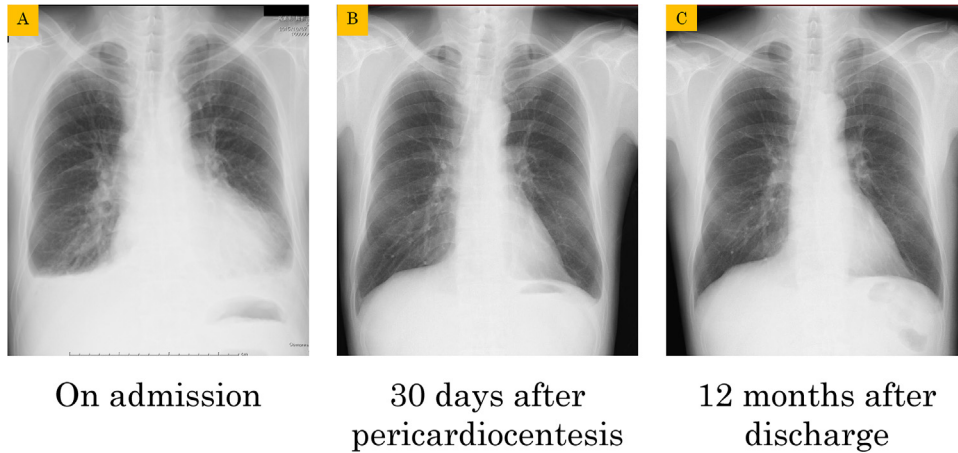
(A) Chest radiography on admission revealed bilateral pleural effusion and an enlarged cardiac shadow with a cardiothoracic ratio of 64%. Chest radiography after the 30 days following the pericardiocentesis procedure (B) and 12 months after discharge (C). There was no re-accumulation of pericardial effusion.
